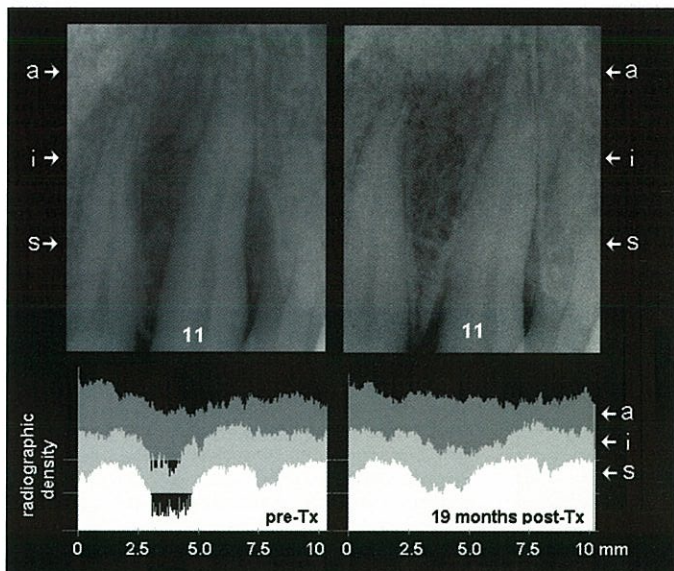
Case 3. Top: Radiograph showing close-up of tooth No. 11 before treatment (left) and 19 months post-treatment. Teeth were aligned and gray scales balanced using Emago software. Three areas of density profiles are indicated with (s), (i), and (a). Bottom: Before and after profiles are plotted for sections through superficial (s), intermediate (i), and apical (a) aspects of the alveolar processes mesial and distal to tooth No. 11.
